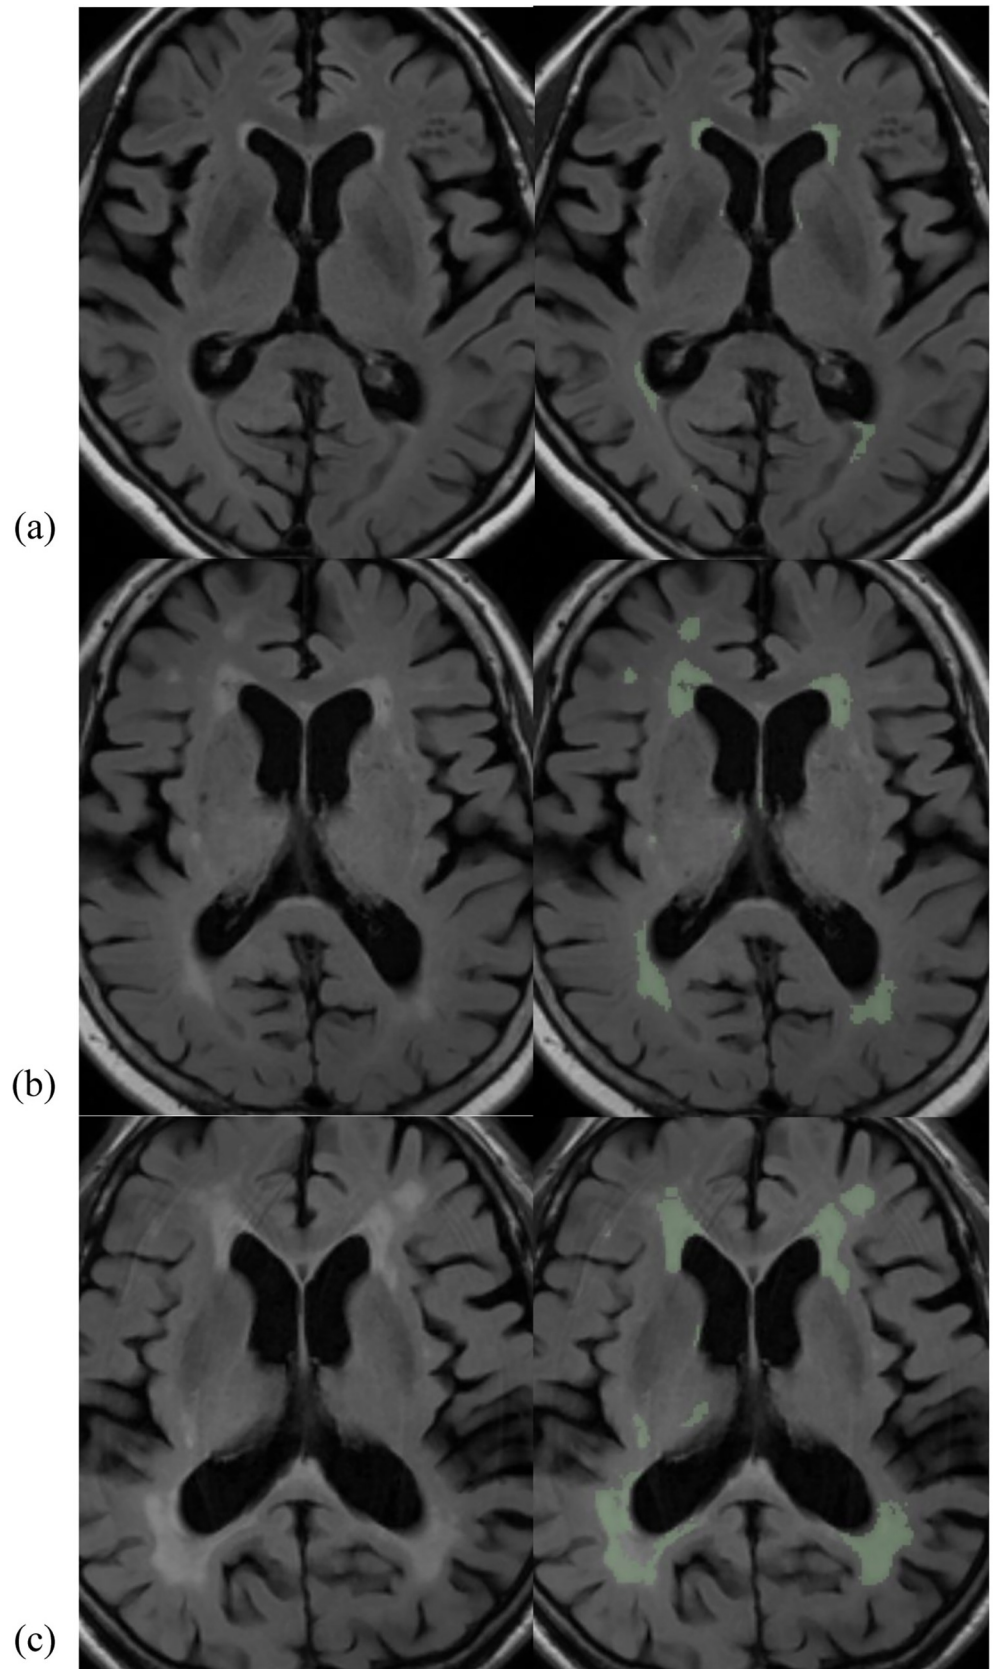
Three pairs of a pre-processed FLAIR image and a mask of segmented WMH with total WMH volume of each case in different Fazekas categories (a-c) (WMH volume: a, 4.11 mL; b, 20.59 mL; c, 47.69 mL, the ratio of WMH volume / total white matter volume: a, 1.09%; b, 5.18%; c, 9.94%). The last pair is the images of a subcortical vascular dementia patient (c). FLAIR, fluid-attenuated inversion recovery.
